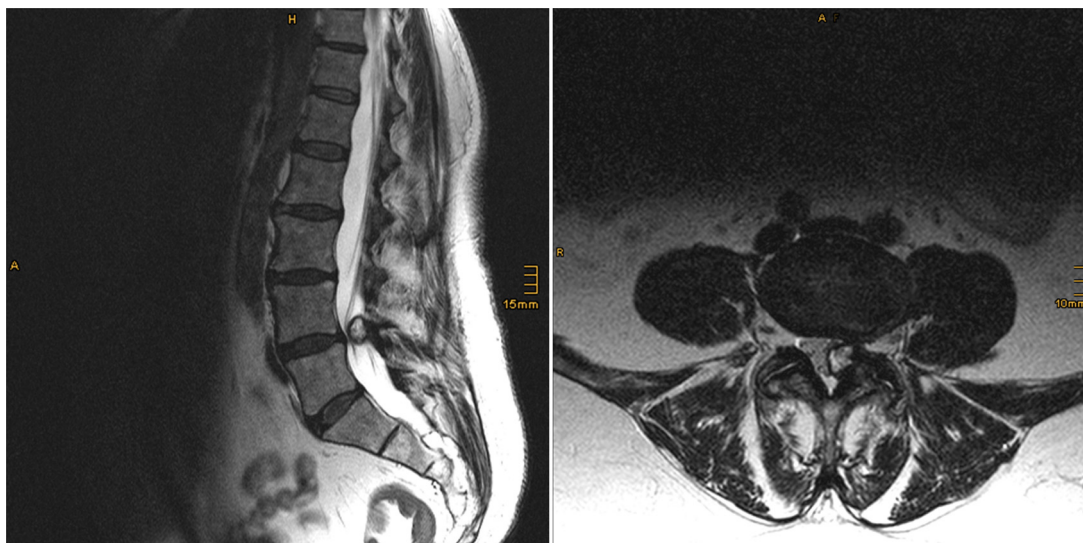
Sagittal and axial T2-weighted MRI of a synovial cyst.
